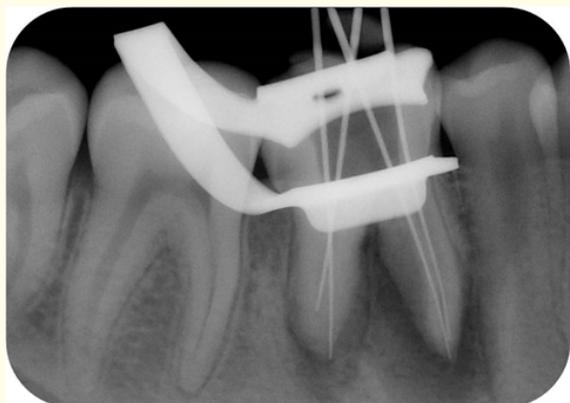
Working length IOPA radiograph of tooth #46 with straight on angulation.
